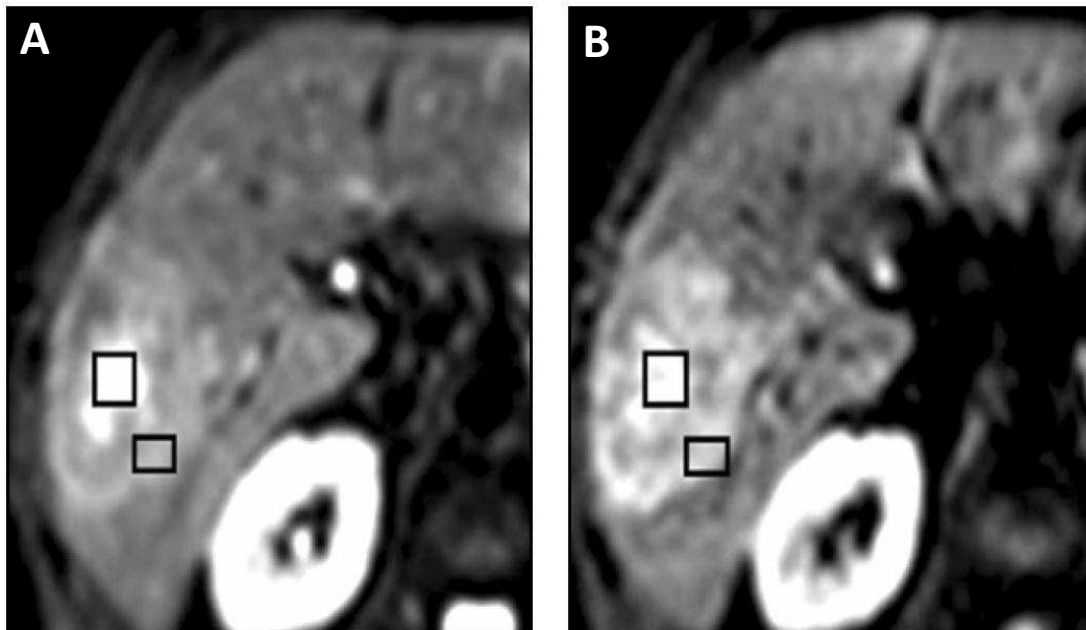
An example of a diffusion-weighted MR images containing liver metastasis. The images are obtained at different b values show large heterogeneous metastasis within right lobe of liver. Necrotic center of metastasis (squares) shows attenuation of signal intensity with increasing b values, indicating less restricted diffusion. By comparison, rim of tumor (rectangles) is more cellular and shows little signal attenuation with increasing b value [2].
